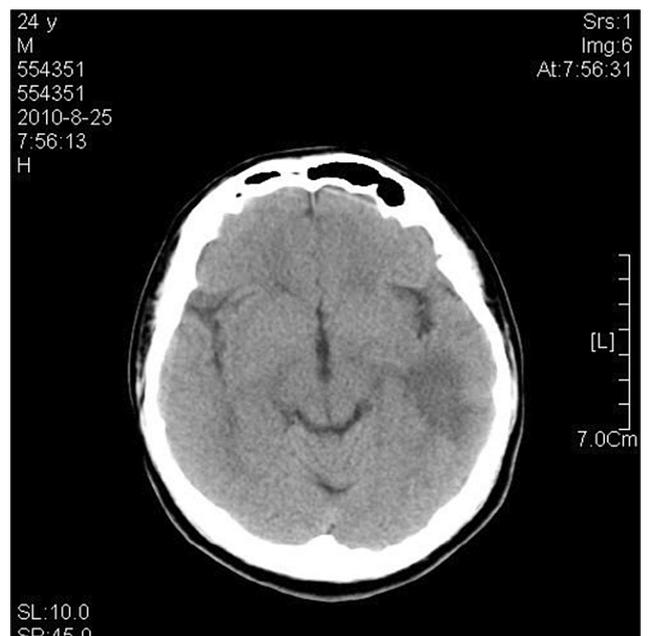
Cranial CT prior to antibiotic treatment showing low-density shadow in the left temporal lobe.
